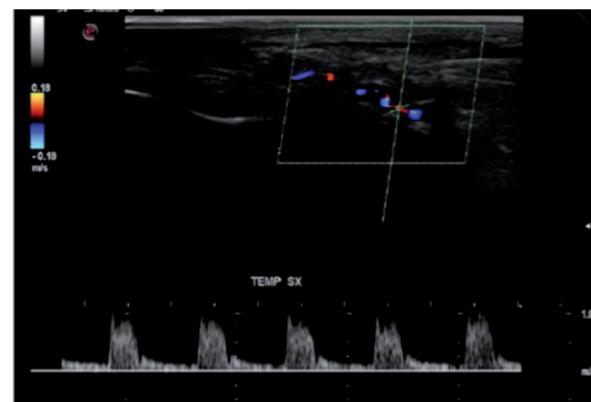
Longitudinal view of the right TA by color Doppler ultrasonography (CDUS) shows a hypoechoic halo of the TA and the presence of turbulent and weak flow, suggesting the presence of stenosis. The PSV is 1 m/s, that is double compared to the segment without stenosis. [11].
